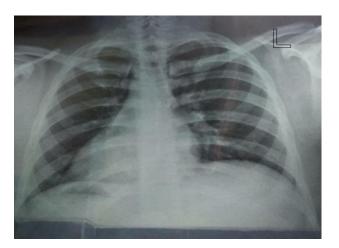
Chest X-ray showing heart in the right side with fundal shadow below it.
